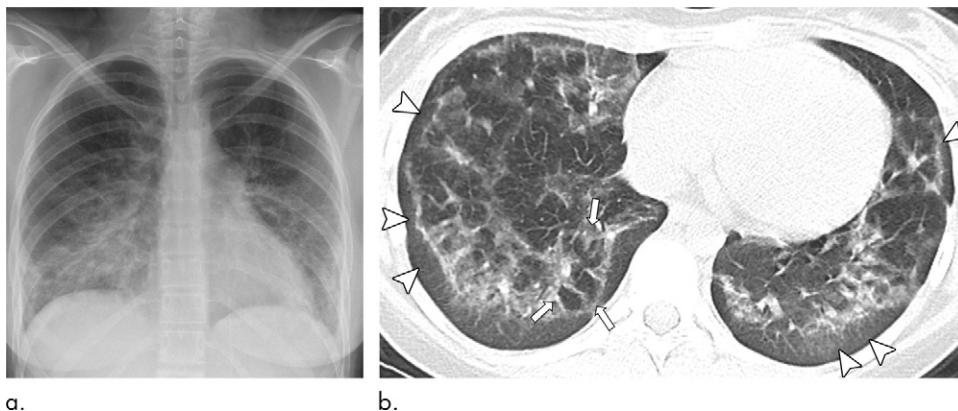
Images in a 16-year-old girl with history of electronic cigarette product use for 1 year and tetrahydrocannabinol dabbing for 2 months who presented with cough, weight loss, nausea, and vomiting for 3 weeks. (a) Posteroanterior digital chest radiograph from day of presentation shows bilateral symmetric ground-glass opacities with consolidation and lower lobe predominance. (b) Axial lung window (width, 1500; level, –700) image of noncontrast chest CT performed on day of presentation demonstrates bilateral ground-glass opacities with subpleural sparing (arrowheads) and reversed halo sign (atoll sign) (arrows) in right lower lobe.
